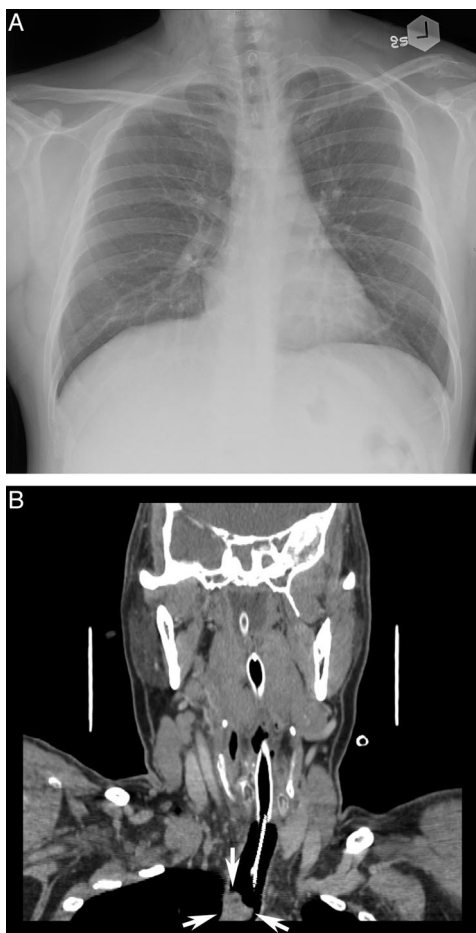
A: Chest radiograph shows normal lung fields. B: Computed tomogram of the neck and upper thorax shows a tracheal mass in the lower trachea.
